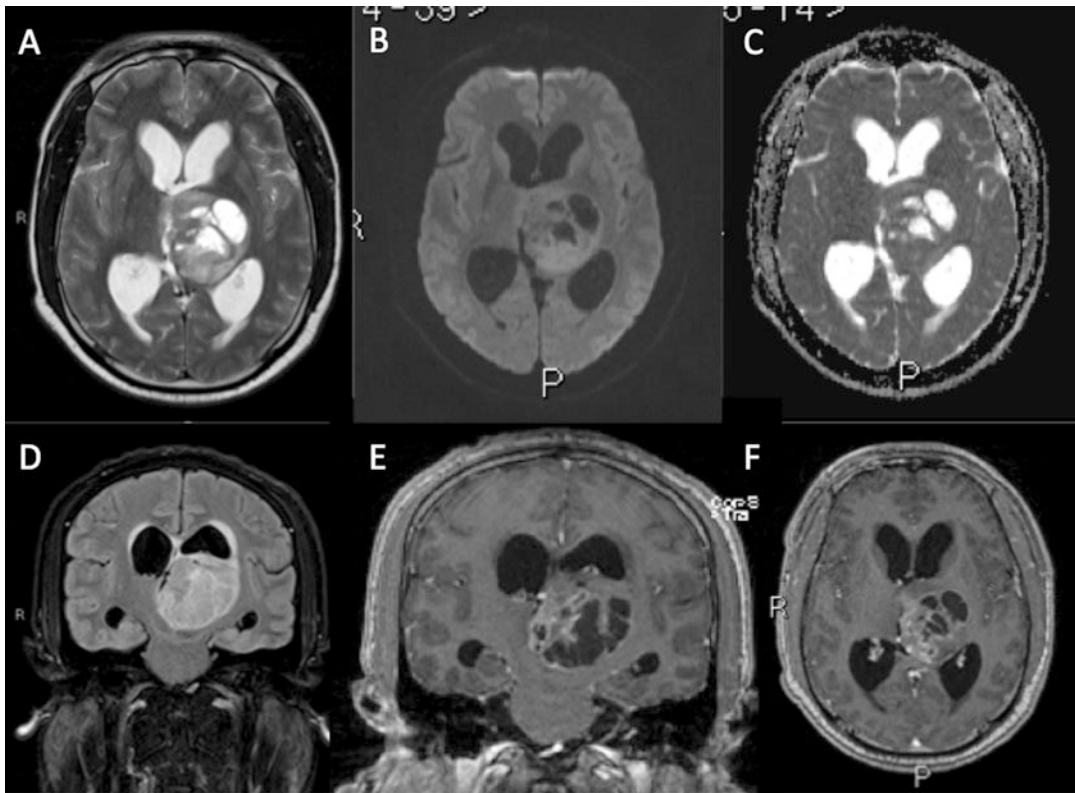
T2w (a), b1000 DWI and ADC map (respectively, b and c), FLAIR (d), and T1w + Gad images (e, f) in a teenage patient with diffuse midline glioma, H3 K27 M- mutant (WHO grade IV). Rapid growth of this highly malignant tumor has resulted in obstructive hydrocephalus
